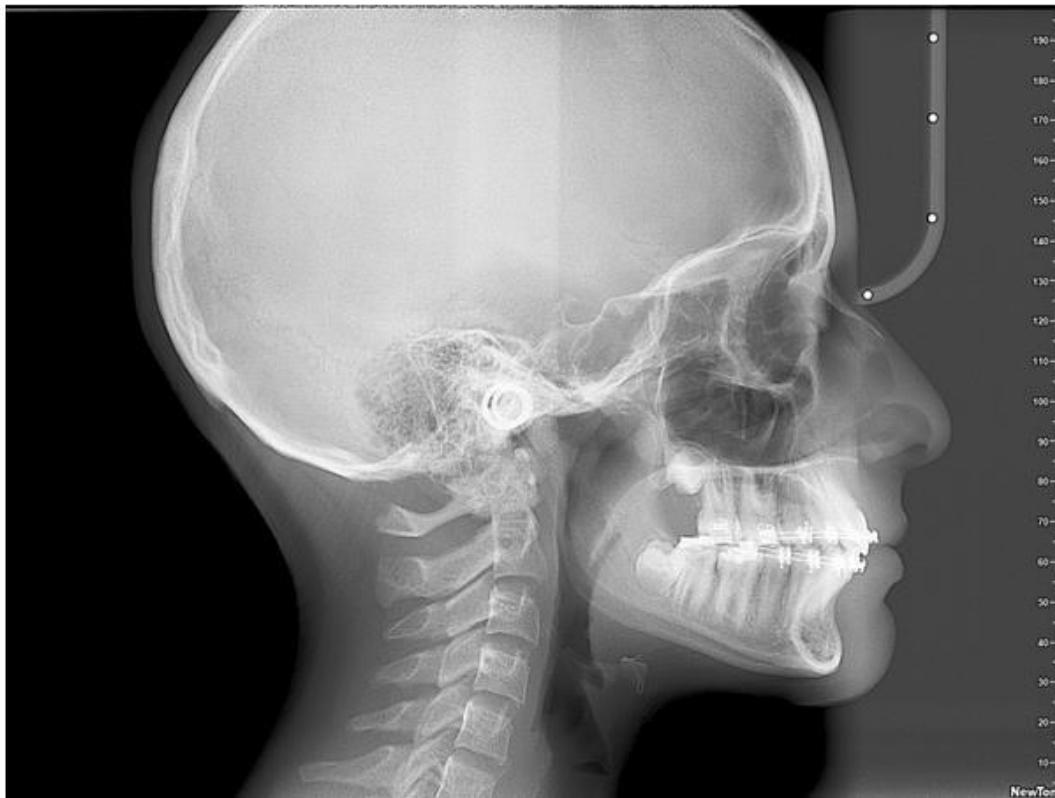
(a) Post-treatment extra-oral and intra-oral photographs; (b) Post-treatment panoramic and lateral cephalometric radiographs.
